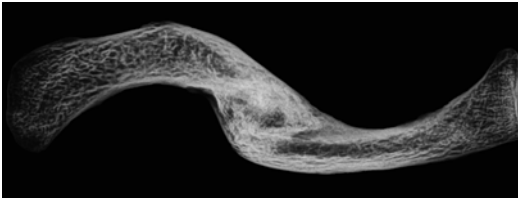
X-rays of the clavicle show shortening of the segment but good healing after fracture
